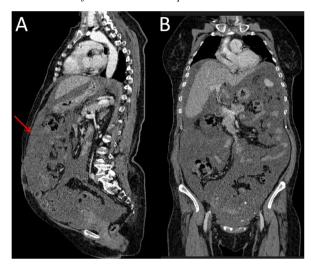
A and B, thoraco-abdominal sagittal and coronal CT scans show an important amount of ascites within the intraperioneal spaces, mesentery, and omentum. Note the omental caking on the sagittal view (red arrow).
